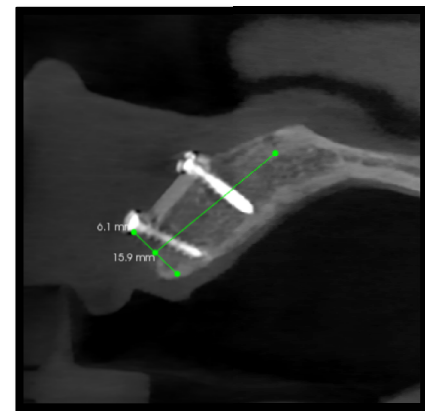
Four months postoperative CBCT section showing increased width of ridge.
